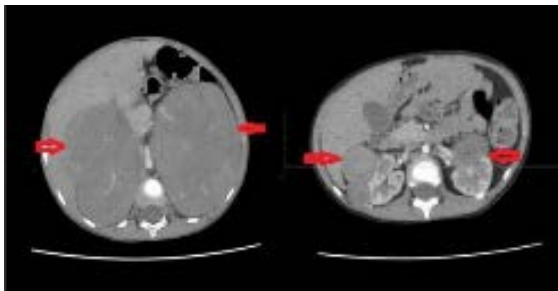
Axial CT scans showing bilateral renal masses before chemotherapy (left), with clear lesions in both kidneys, and after chemotherapy (right), with the tumors getting much smaller
